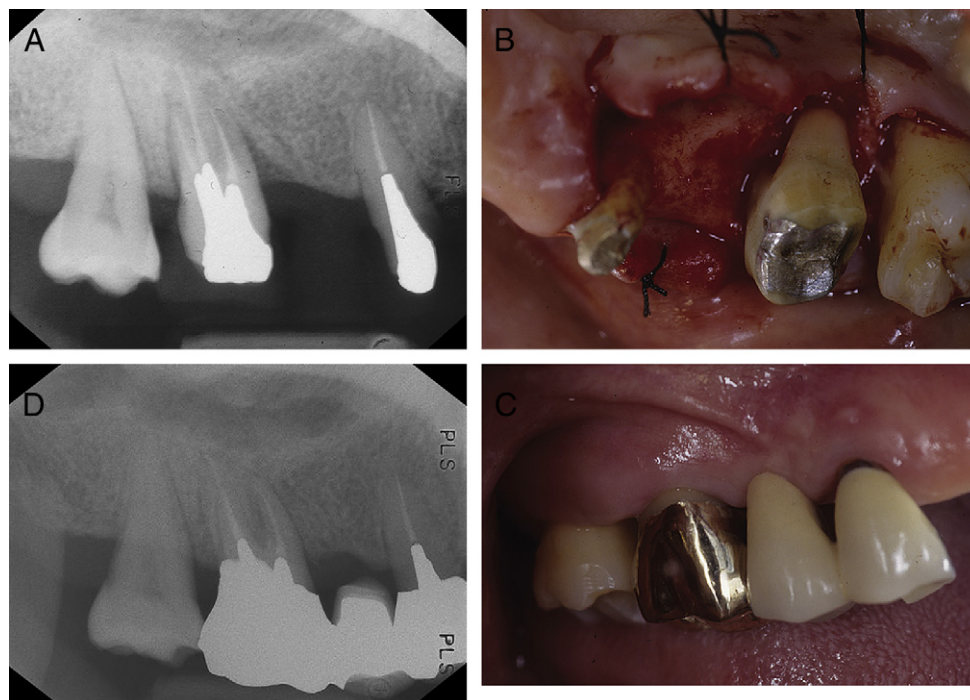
(A) Ten-month follow-up radiograph after the first GTR procedure. (B) Remaining bony defect at 10-month re-entry surgery. (C) Final prosthesis delivered 5 months later. (D) Ten-month follow-up radiograph after the second GTR procedure.
